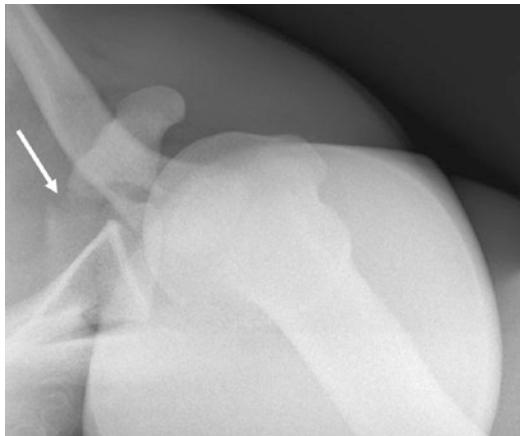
Nineteen-year-old man with initially missed coracoid fracture. AP internal and external rotation radiographs are normal (not shown). Trans-scapular Y view demonstrates a mildly displaced coracoid base fracture (arrow)
